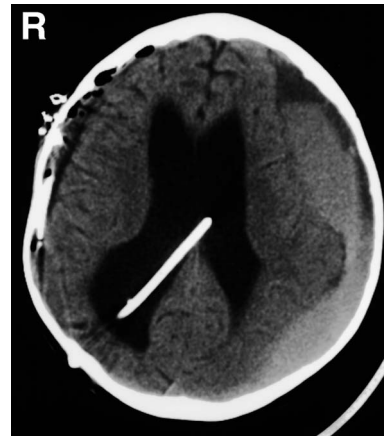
Computed tomography scan obtained at follow-up examination 2 days after right burrhole trephination demonstrating left subdural hematoma.
